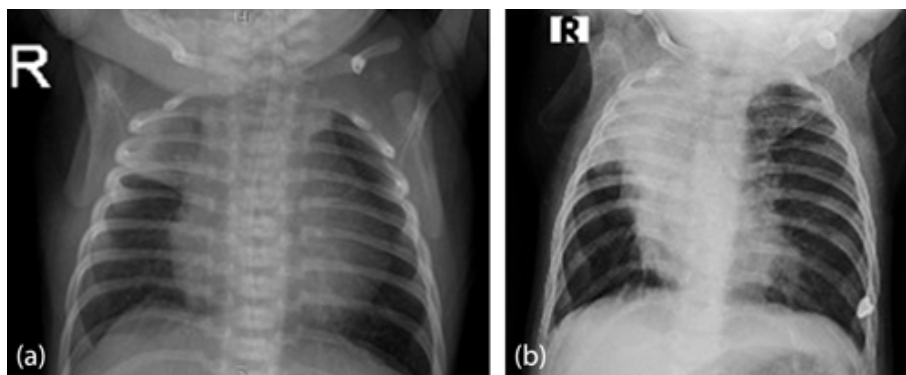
(a) Chest radiograph showing right upper lobe opacification and partial collapse at 12 hours of life. (b) Worsening of the right upper lobe collapse at 5.5 months of life with new hyperinflation of the aerated right and left lungs. ↩
